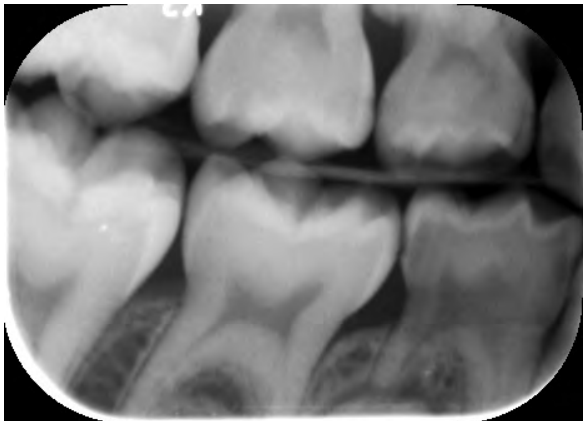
Right bitewing, ZA.
